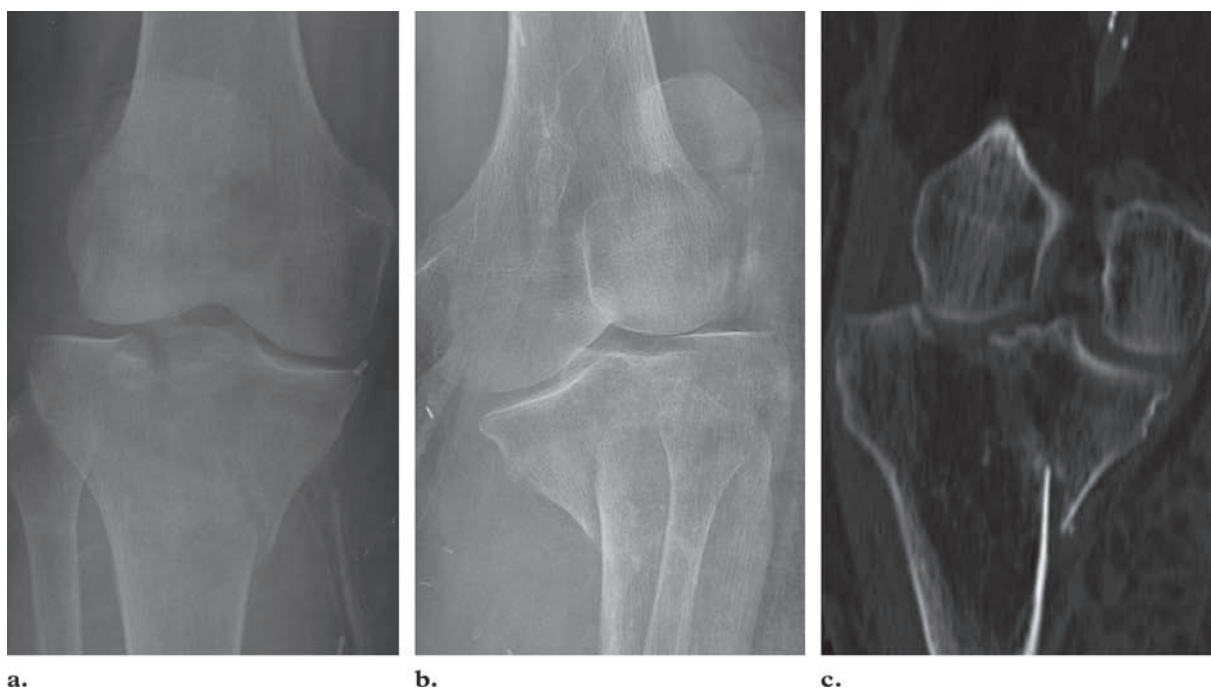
Type IV fracture in an 80-year-old woman who was in a motor vehicle accident and presented with open fractures of the knee. (a, b) Posteroanterior (a) and lateral (b) radiographs of the knee show an appearance suggestive of a bicondylar tibial plateau fracture (Schatzker type V fracture). A fracture of the patella is also noted. (c) Coronal CT image shows only a fracture of the medial tibial plateau, a type IV fracture. There is also lateral subluxation. Initially, the open fractures were irrigated and débrided, and an external fixator was placed. Subsequently, definitive surgical reduction and internal fixation along with partial patellectomy were performed.
